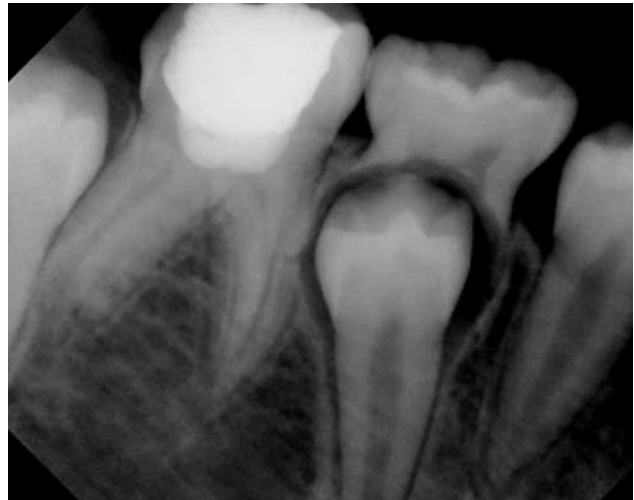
Postoperative radiograph of case no. 2 at 19-month recall (healing).
